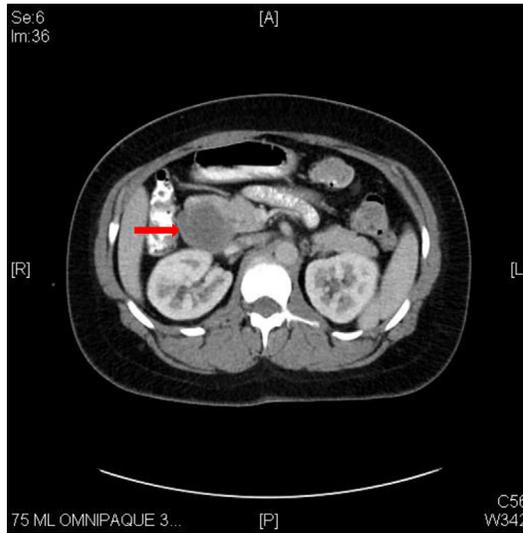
Contrast-enhanced CT scan of a patient with metastatic gastrinoma to the periduodenal space. A 5-cm lesion adjacent to the duodenum was identified (*arrow*); biopsy was consistent with neuroendocrine tumor, and the lesion was the only site localized on octreotide scan. On surgical exploration, a primary tumor measuring 5 mm was identified in the duodenal wall.
